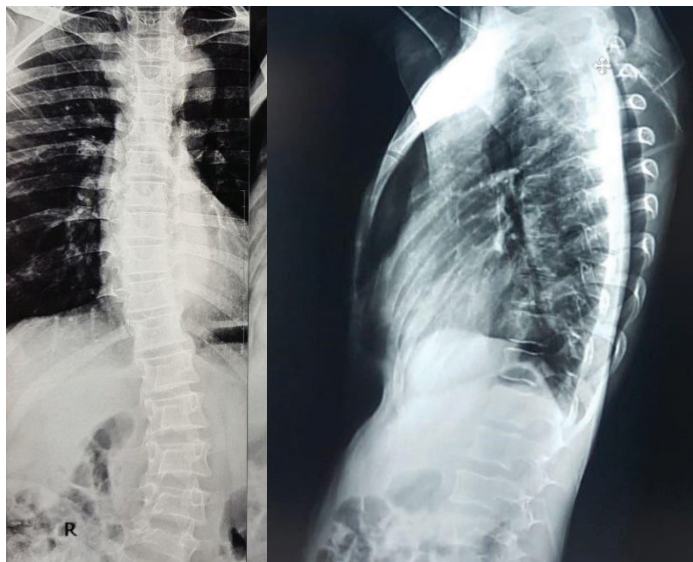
Xray chest (Anteroposterior and Lateral view) showing Thoracolumbar scoliosis with cardiomegaly
